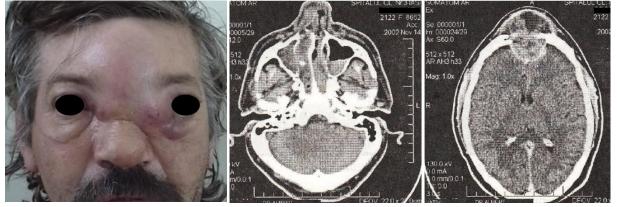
Preoperative image Figure 89. Head CT scan showing tumor with intracranial (*Assoc. Prof. Dr. M. D. Turliuc's* extension (from *Costinescu et al., 2003*) personal collection)
